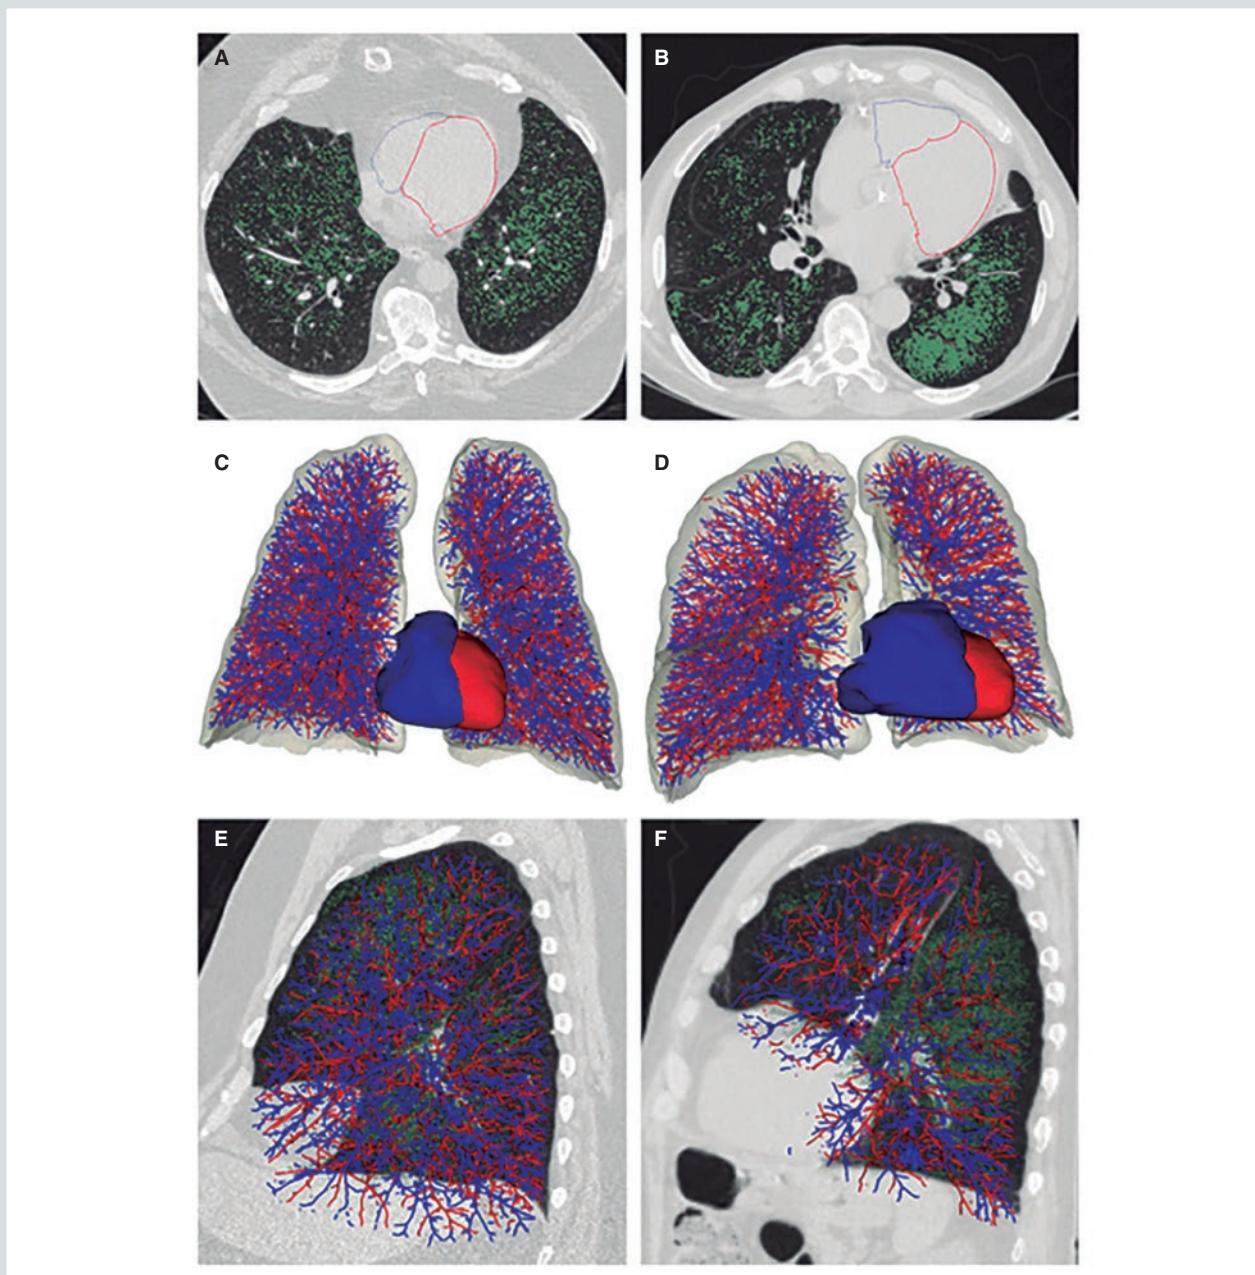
Pulmonary vasculature and right (blue) and left (red) ventricular reconstructions from computed tomography images for two subjects with approximately 20% emphysema on computed tomography scan. (A, C, and E) Subject 1 with 19% emphysema and relative preservation of the distal arterial vascular volume (arterial volume for vessels less than 5 mm² in cross-section = 131 ml). (B, D, and F) Subject 2 with 18% emphysema and relative loss of the distal arterial vascular volume (arterial volume for vessels less than 5 mm² in cross-section = 70.8 ml). (A and B) Axial images of the epicardial surface of the right ventricle (RV), which is outlined in blue and the epicardial surface of the left ventricle, which is outlined in red. Emphysema is depicted in green. (C and D) Frontal view of the arterial (blue) and venous vasculature and the surface model of the epicardial (myocardium and chamber) RV volume (blue) and epicardial (myocardium and chamber) left ventricular volume (red). The epicardial (myocardium and chamber) RV volume of Subject 1 is 58.9 ml and the epicardial (myocardium and chamber) RV volume for Subject 2 is 140 ml. (E and F) Sagittal views of the arterial (blue) and venous (red) vasculature of the left lung demonstrating the relative loss of distal arterial vascular volume. Emphysema is shown in green (reprinted from Washko et al.³⁸ with permission of the American Thoracic Society, © 2020 American Thoracic Society).
